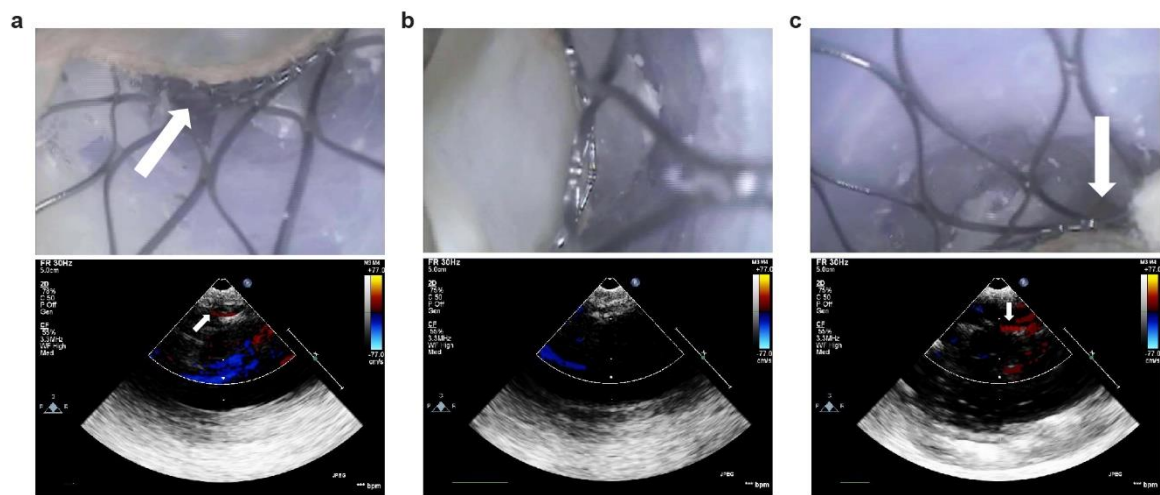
Detection of potential paravalvular leak sites (indicated by the white arrows) in the 3D printed aortic root model with implanted valve and corresponding color Doppler echocardiograms in (a) region 1, (b) region 2, and (c) region 3.
